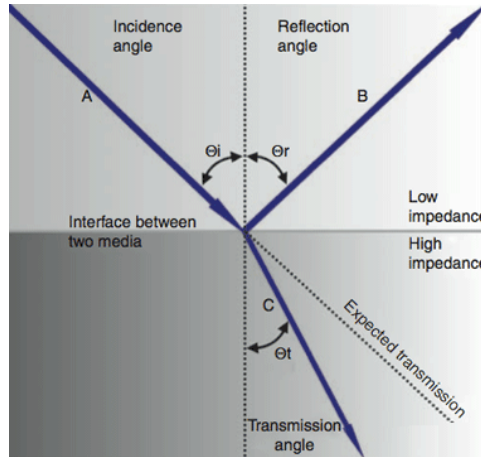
Reflection and refraction of the ultrasound beams [20].
